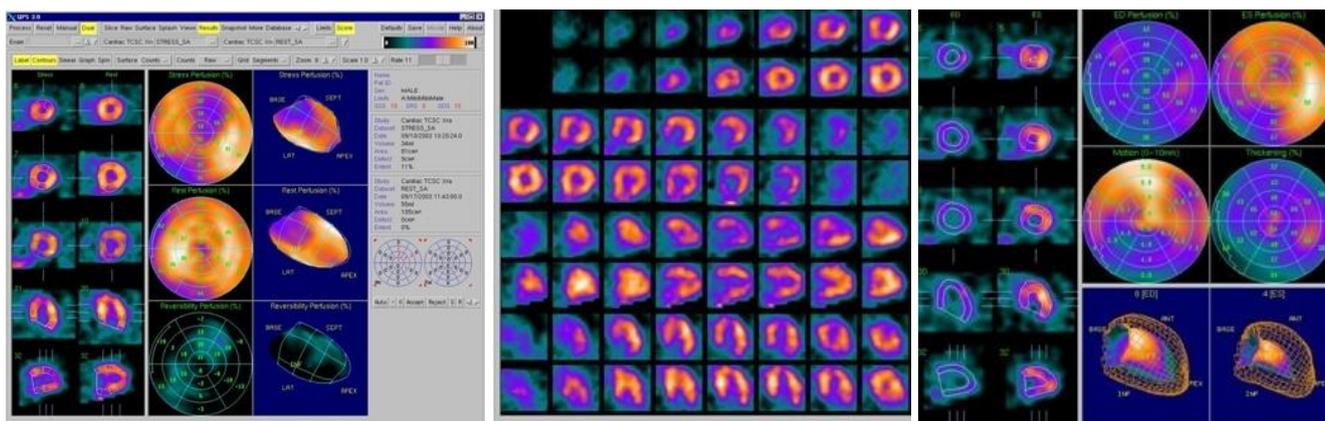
SPECT-SCA patient (1947) after non-ST-elevation myocardial infarction, exertional angina pectoris, poor physical load tolerance (own source).
